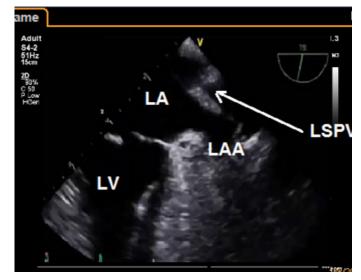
Transesophageal echocardiography. Midesophageal view at 75 degrees. Between the LAA and LSPV the ridge is present, which is an important structure for catheter ablation of atrial fibrillation because in order to isolate the LSPV, multiple RF applications should be done at this level.
